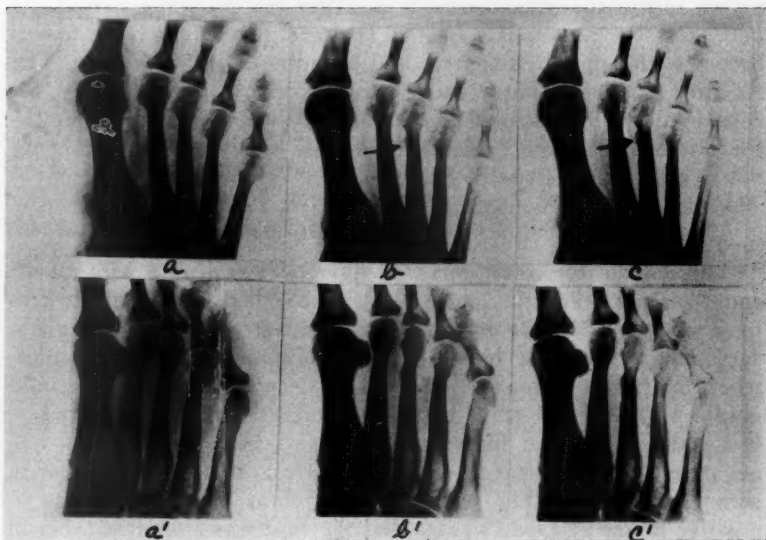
a, Negative roentgenogram 8 days after onset of symptoms, anteroposterior view. a', oblique view. b, Roentgenogram 21 days after onset, note slight periosteal fuzziness, anteroposterior view. b', oblique view. c, Roentgenogram 27 days after onset; anteroposterior view; note increased amount and density of callus. c', oblique view.
